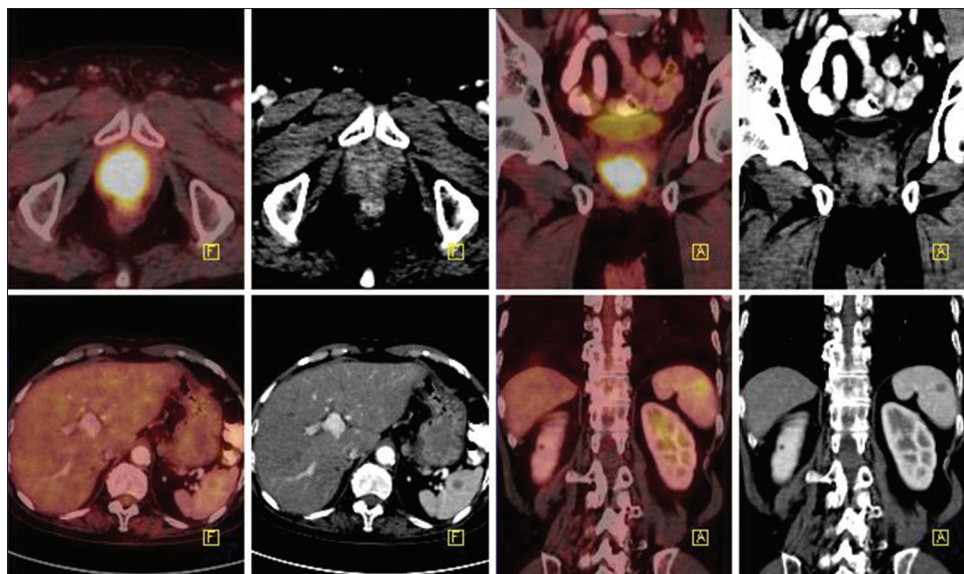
A means coronal view (anterior to posterior), F means axial view (feet to head) positron emission tomography-computed tomography fused and contrast-enhanced computed tomography images: upper axial (left) and coronal (right) images show fludeoxyguucose avid enhancing lesion in prostate gland. Lower axial (left) and coronal (right) images show fludeoxyguucose avid hypodense lesion in spleen
